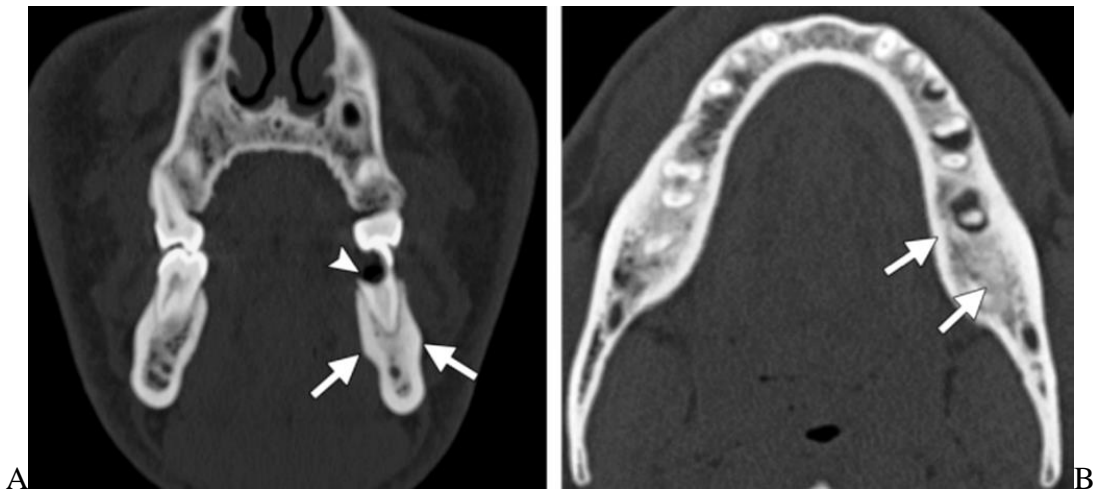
Condensing osteitis in two patients. (A) Coronal CT image shows a poorly marginated nonexpansile sclerotic lesion (arrows), a finding indicative of condensing osteitis. The lesion is associated with a carious lesion (arrowhead). (B) Axial CT image obtained in a different patient shows two poorly marginated nonexpansile sclerotic lesions (arrows) associated with periapical inflammatory lesions, a finding indicative of condensing osteitis.
